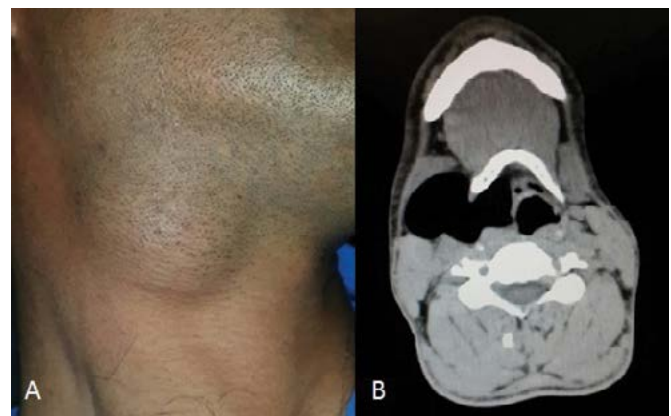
The appearance of the mass located at the right neck region. 1B: An axial CT showed air-filled sac at the right part of the neck.
